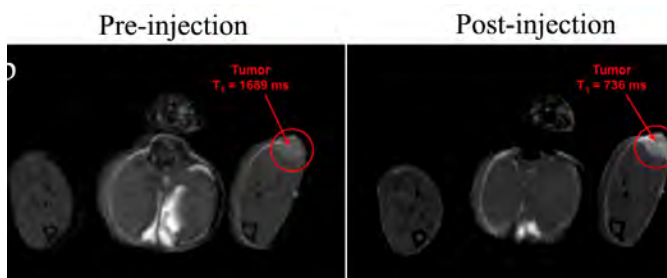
In vivo T<sub>1</sub>-weighted MRI:(a) No hyperintense signal was detected without injection. (b)Hyperintense signals were detected injected with DOX/GQDs-Gd after 2h.
